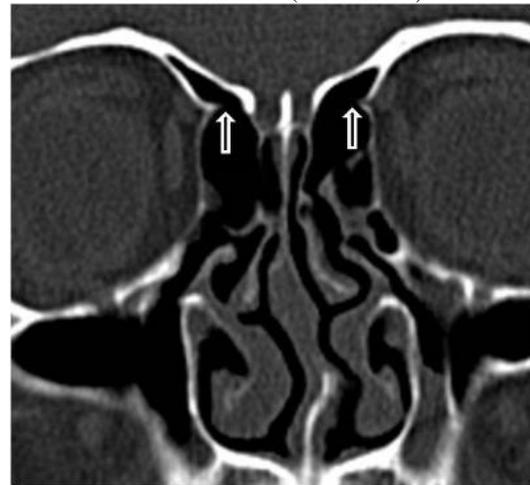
Coronal CT scan shows bilateral dehiscence of anterior ethmoidal artery (White outlined arrows).
